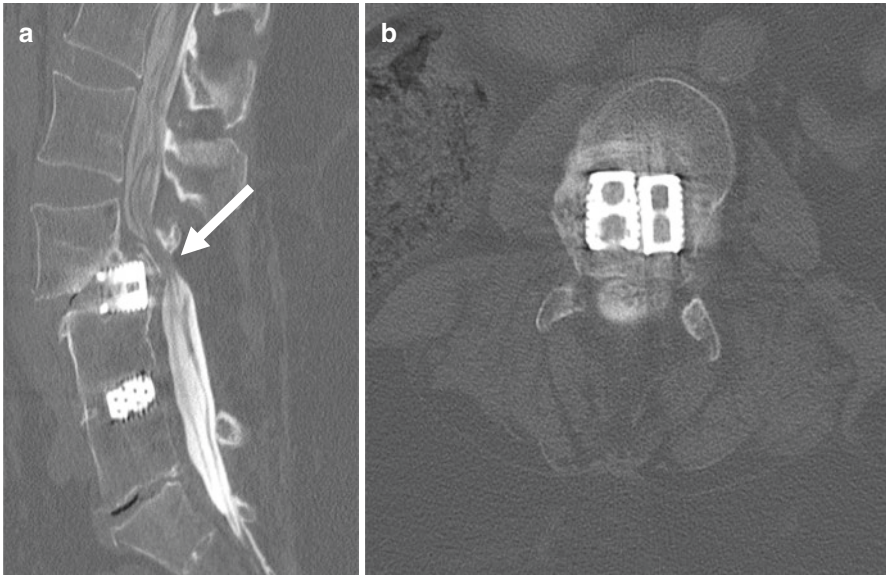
CT myelogram with metal reduction technique. (a) Sagittal reformat and (b) axial image shows thecal sac narrowing (arrow) at L3–L4 with anterolisthesis and interbody spacer despite spinal decompression. There is no evidence of CSF leak
